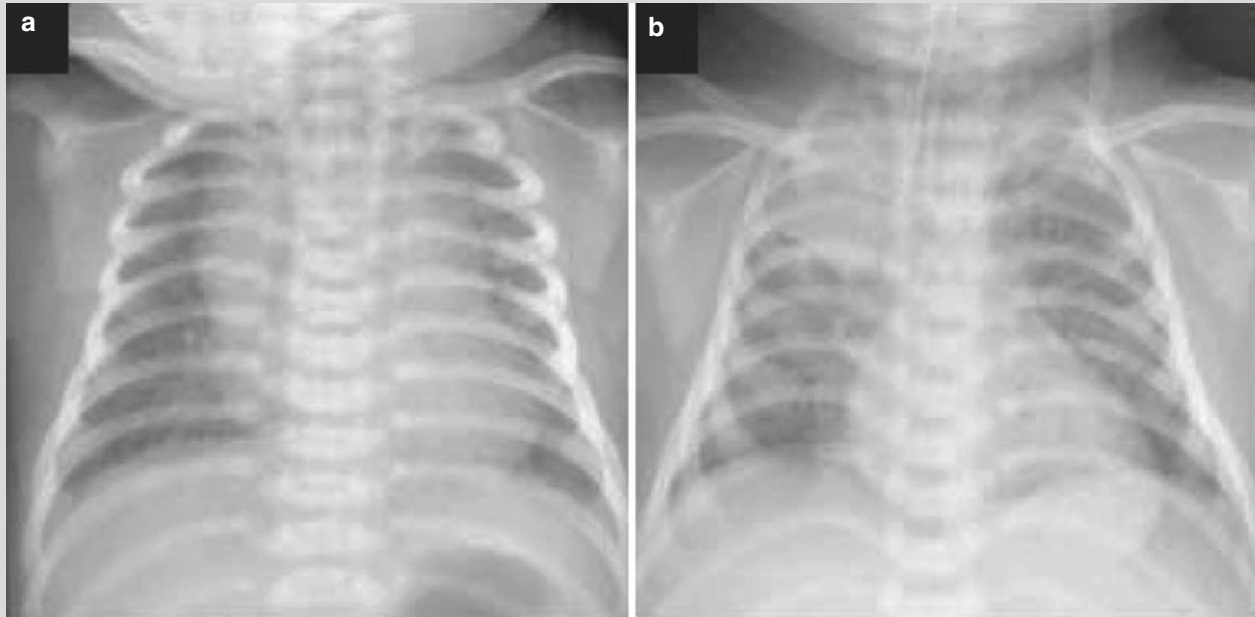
Neonatal tetanus complicated by pulmonary atelectasis (a) Chest X-ray demonstrates no obvious abnormality when hospitalized. (b) By reexamination after 8 days, chest X-ray demonstrates
